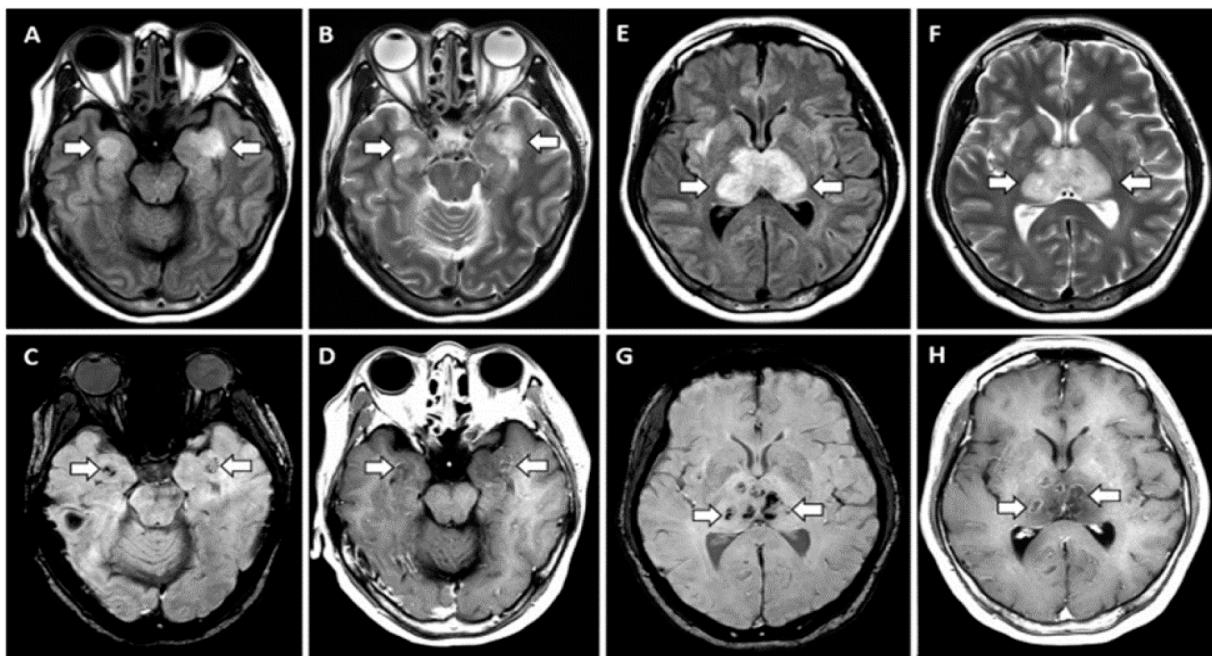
Fluid-attenuated inversion recovery (FLAIR) image shows hyper intensities within the bilateral thalamus and medial temporal lobes (arrows) and also evidence of hemorrhage on C, G, hypo intense signal (arrows) on susceptibility-weighted images(SWI) and rim enhancements in D, H. From Poyiadji N. et al. [148]
